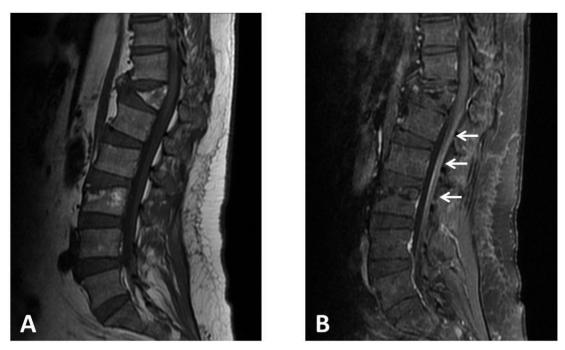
Lumbar-sacral spine MRI without (A) and with (B) gadolinium contrast with arrows to indicate gadolinium contrast enhanced lesions of the conus medullaris and cauda equina nerve roots.
